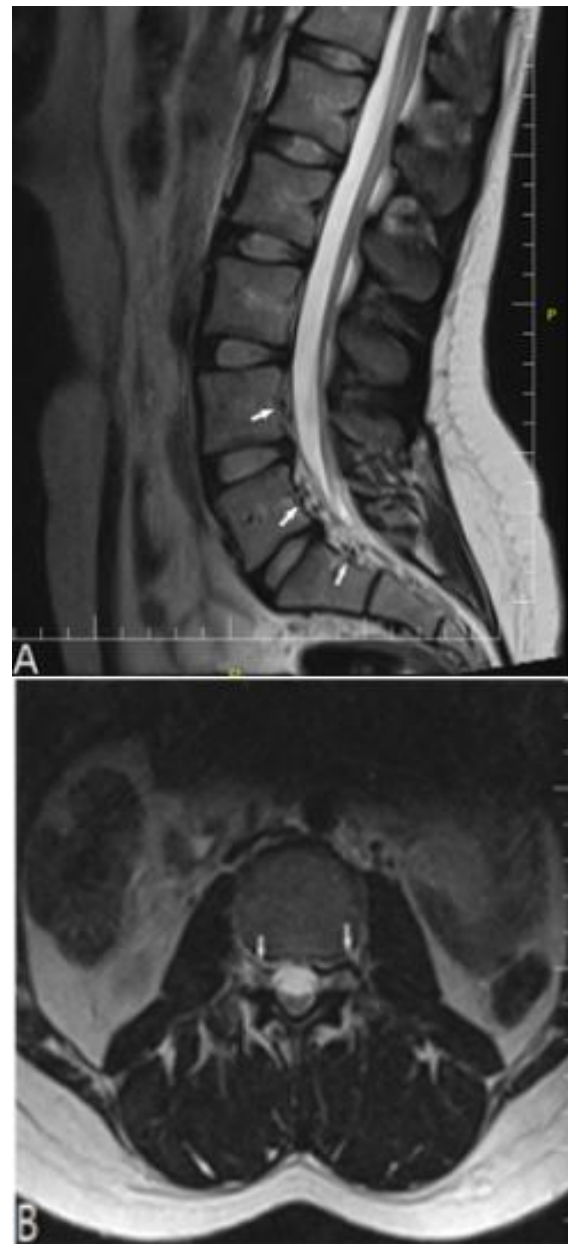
Varices on T2-weighted images sequence are sagittal(A) and axial (B) plane. The white arrows show the lesions.
